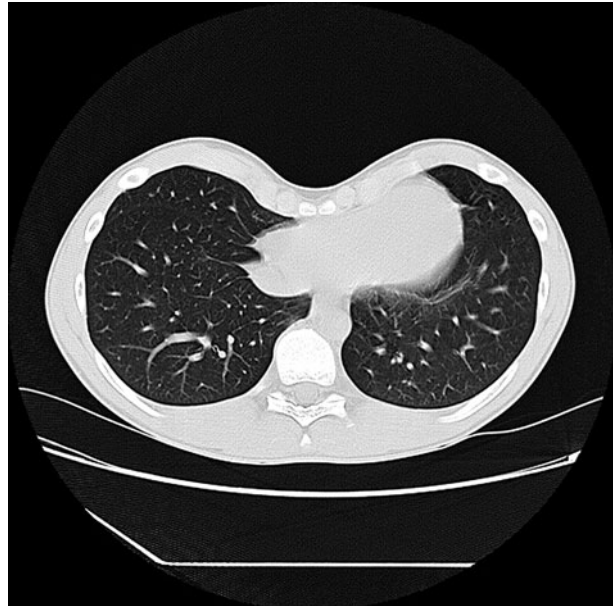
CT scan of the same patient 2 min after evacuation of the vacuum bell
